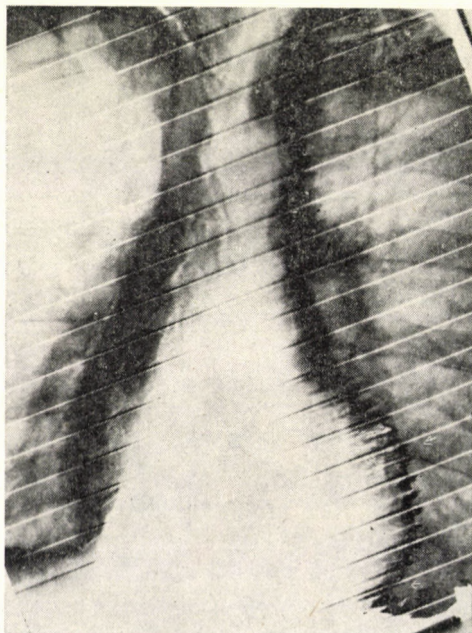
X-ray kymogram: extensive paradoxical pulsation at the apical region and the posterior wall
